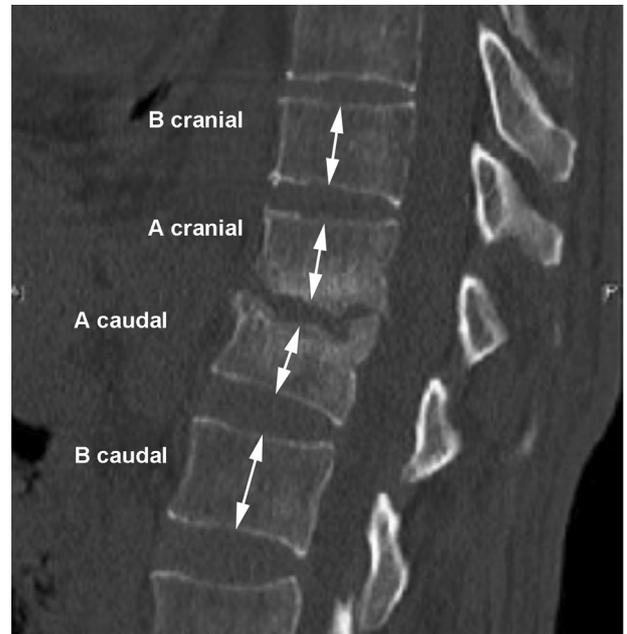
Evaluation of vertebral body height on preoperative CT: the average ratio between A-cranial/B-cranial and A-caudal/B-caudal was calculated.
